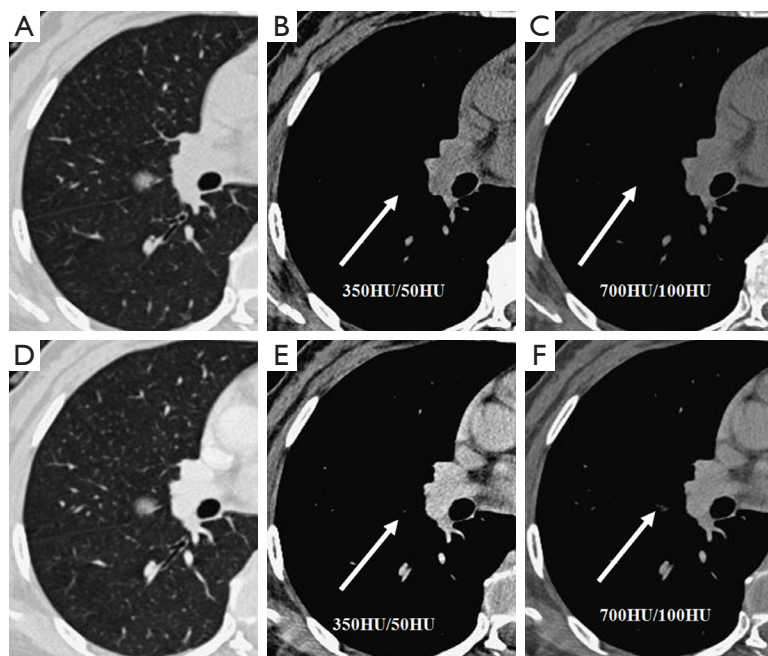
(A-F) A small pGGN diagnosed as AIS by pathology. No solid portions were detected in plain and contrast CT images in CMW and EMW (arrows in A, C, D, and F show the little vessel enhancement within the nodule that should not be considered as nodule enhancement). The enhancement of this nodule manifested as evaluation of mean CT values. The mean CT values in (A) unenhanced CT image and (D) enhanced CT image were  $-351$  and  $-232$  HU, respectively. CT, computed tomography; pGGNs, pure ground glass nodules; CMW, conventional mediastinal window; AIS, adenocarcinoma in situ; EMW, extended mediastinal window.
